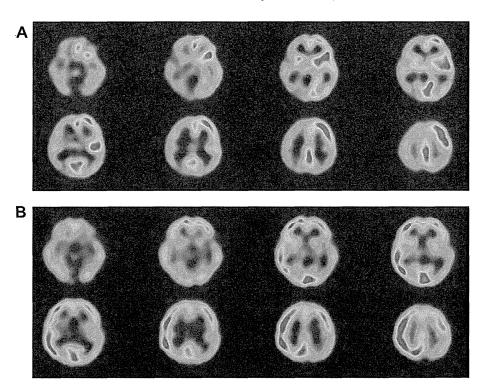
Single photon emission computed tomography using 99mTc-ethyl cysteinate dimer 7 (A) and 35 (B) days after the onset of encephalopathy.
